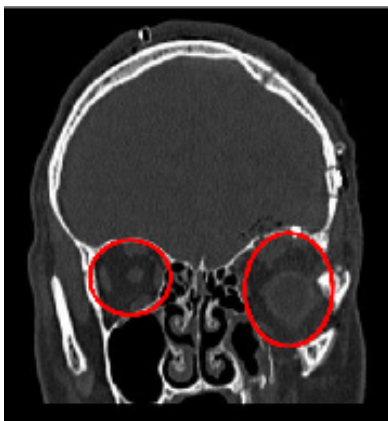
Coronal CT scan views of lateral wall and orbital floor fracture, increase of the orbital volume is obvious.
